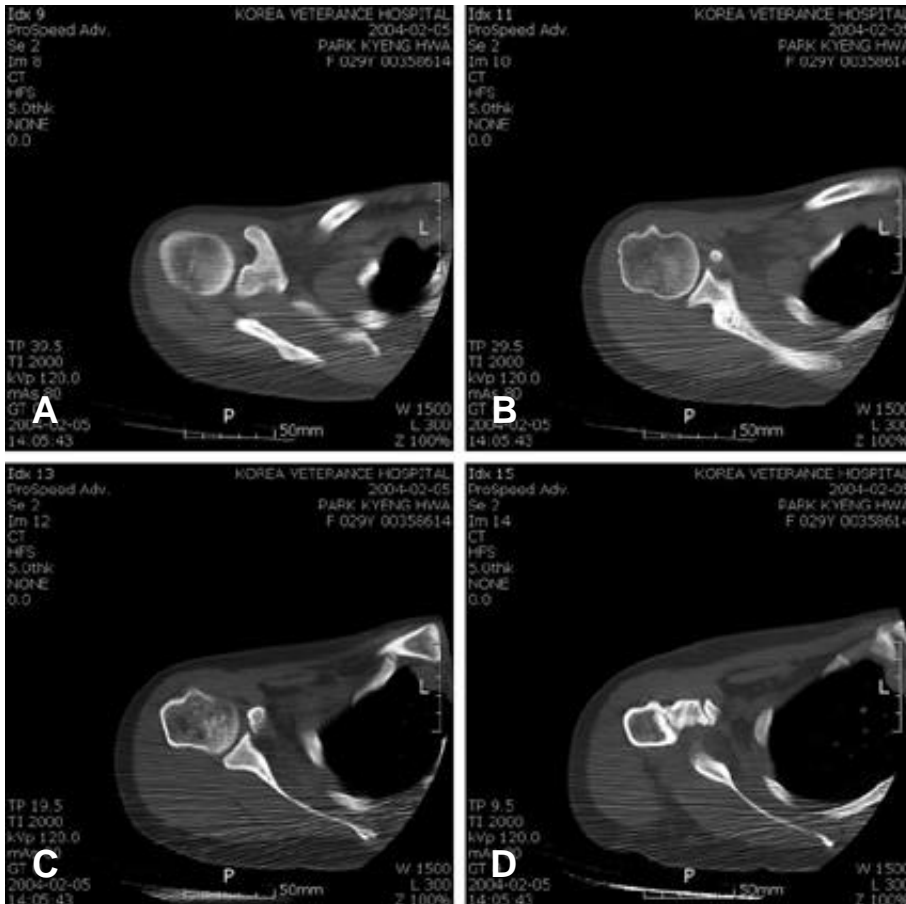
CT scans of the shoulder showing the mass in the subscapularis muscle.
